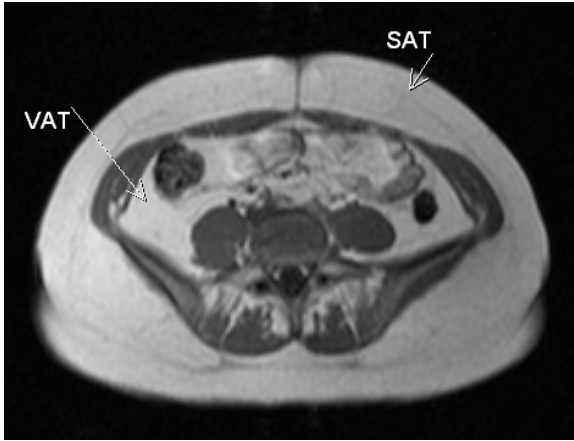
Transaxial T1-weighted GE acquisition at the level of L5. SAT is subcutaneous adipose tissue, VAT is visceral adipose tissue.
